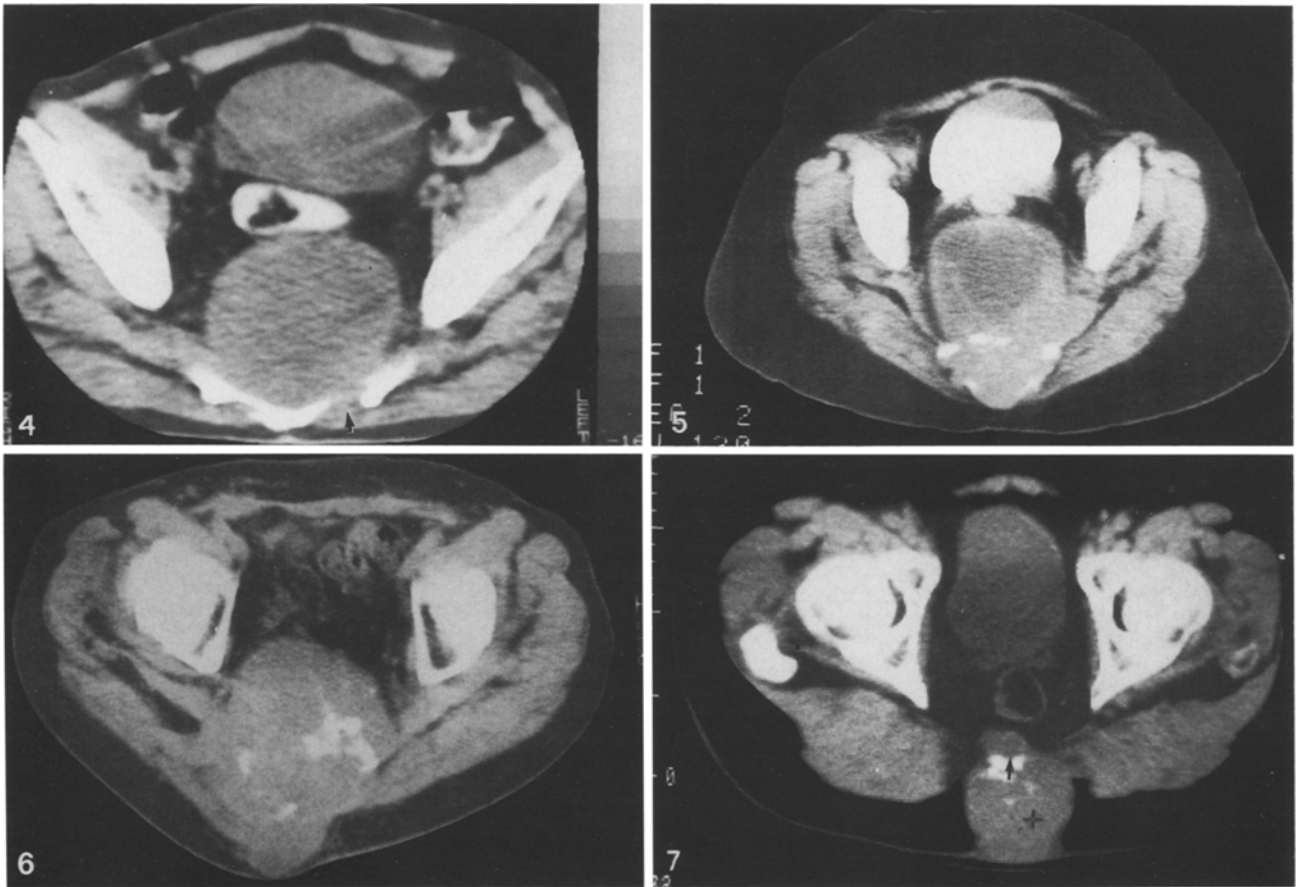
CT. Bulky tumor with small area of destruction involving sacral foramen (arrow)
